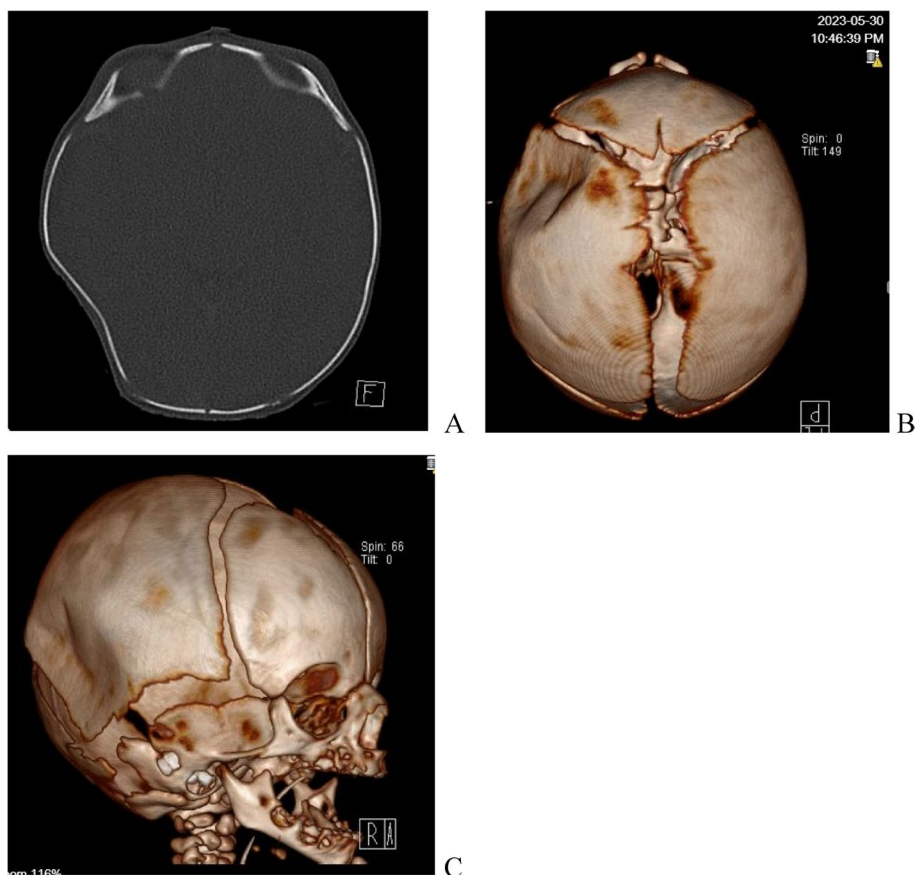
CT scan A and 3D computed tomography scan reconstruction B, C showing the depressed skull fracture involving right temporoparietal bones
